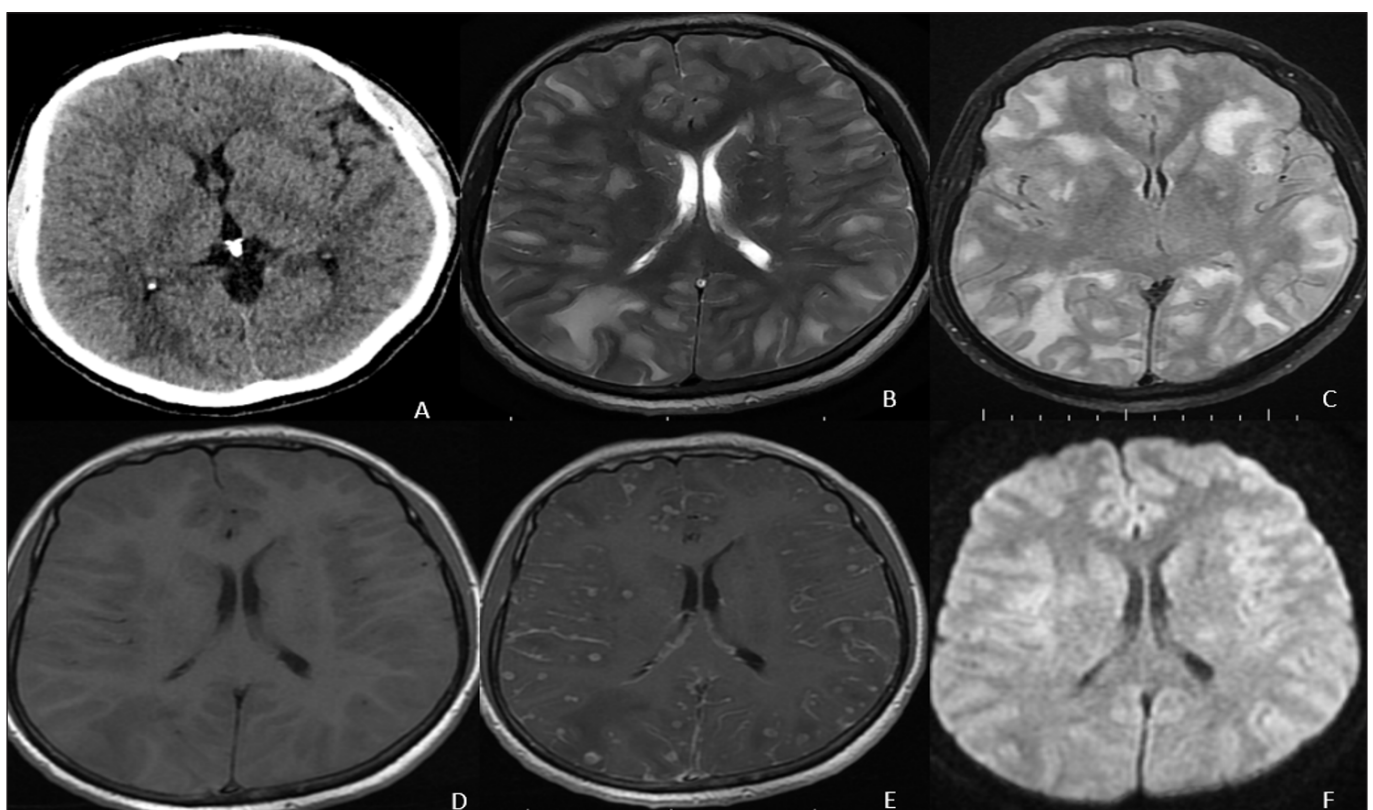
A case of miliary brain metastasis due to lung adenocarcinoma (Patient 1). (A): Axial non-enhanced CT; (B): Axial T2-weighted; (C): FLAIR; (D): Pre-contrast axial T1-weighted; (E): Post-contrast axial T1-weighted; (F): Diffusion weighted images.
